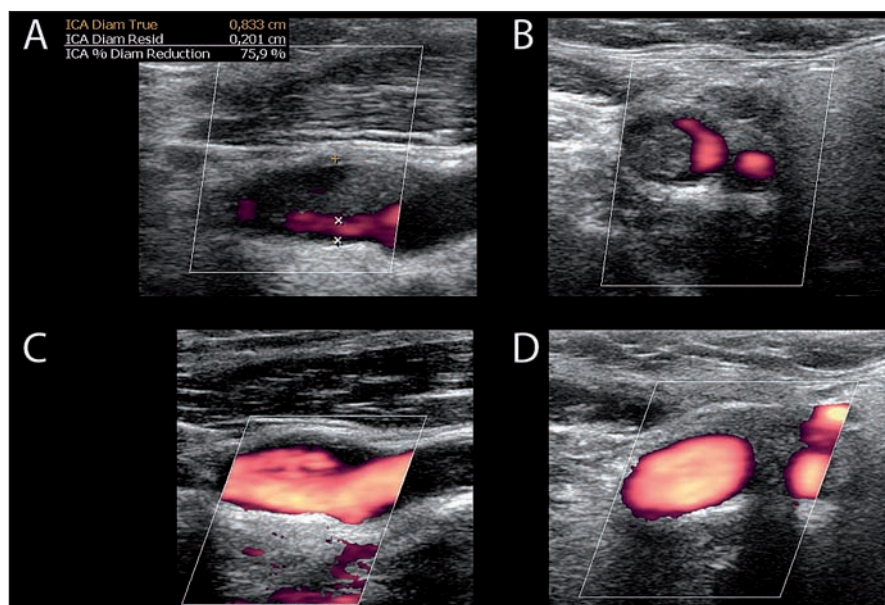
Carotid ultrasonography of left internal carotid artery demonstrates thrombus and 75% stenosis on longitudinal (A) and transverse (B) views. After nine days, repeated carotid ultrasonography shows complete thrombus resolution on longitudinal (C) and transverse (D) views.
